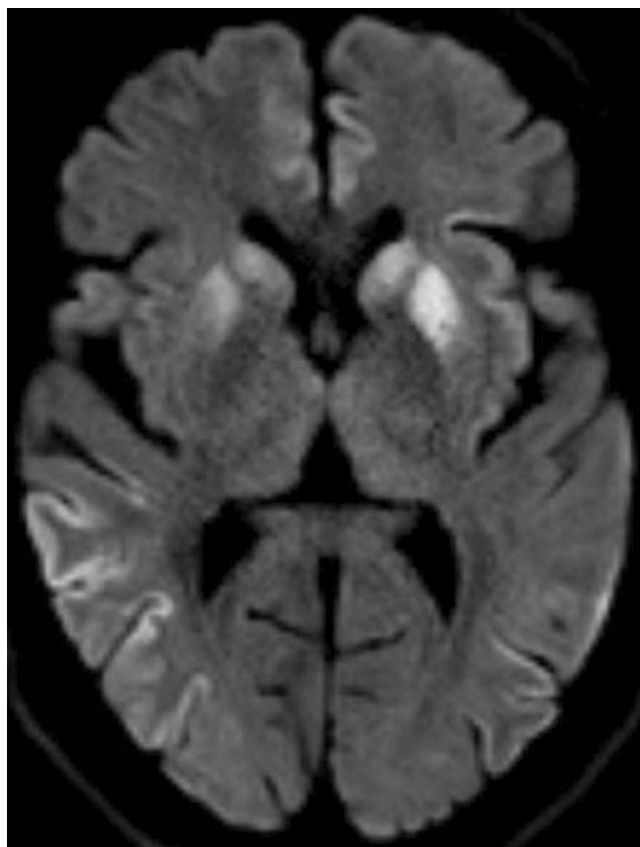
Magnetic resonance imaging (MRI) of sporadic CJD. A 71-year-old woman with 1 year of memory loss, worsening executive dysfunction, and gait difficulties. Gait ataxia and mild parkinsonism on examination. DWI images show cortical ribboning of multiple cortical structures and hyperintensity of the deep nuclei bilaterally
